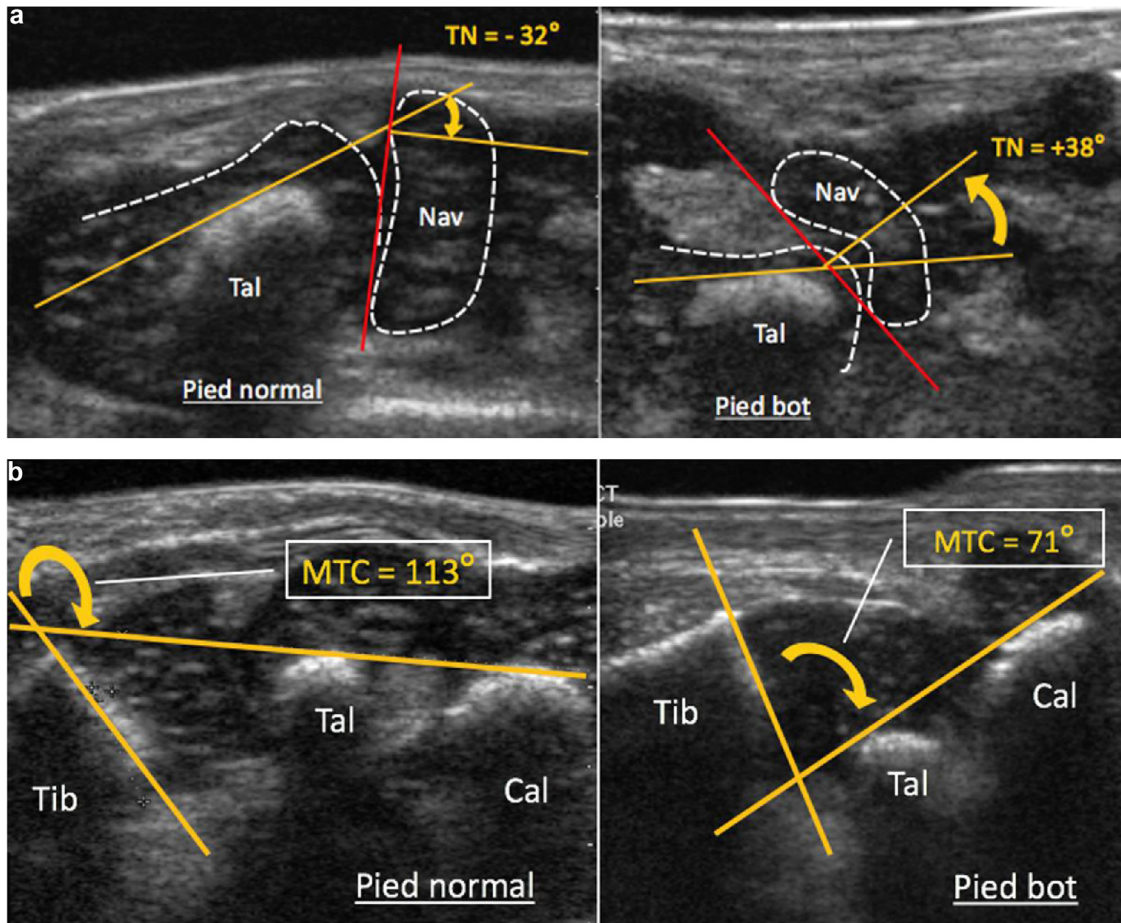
a: medial axial ultrasound projection allowing measurement of the talo-navicular (TN) angle. Normal foot on the left and clubfoot on the right. Tal: talus; Nav: navicular; TN: talo-navicular angle. b: Sagittal posterior ultrasound projection allowing measurement of the metaphysis- talo-calcaneal angle. Normal foot on the left and clubfoot on the right. Tib: tibia; Tal: talus; Cal: calcaneus.
